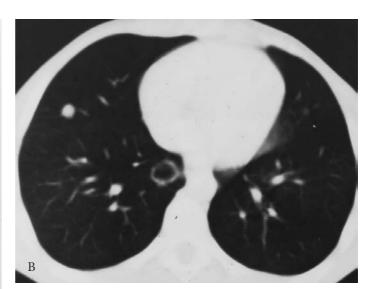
Diffuse papillomatosis. A, Lateral tomogram of the larynx and cervical region reveals diffuse nodularity throughout the larynx and proximal trachea, with partial obstruction of the lumen. B, A chest computed tomography scan reveals small pulmonary nodules and a cavitary nodule in the right lower lobe, consistent with pulmonary papillomatosis. Posteroanterior (C) and lateral (D) chest radiographs demonstrate bilateral pulmonary nodules, some of which are cavitary.
